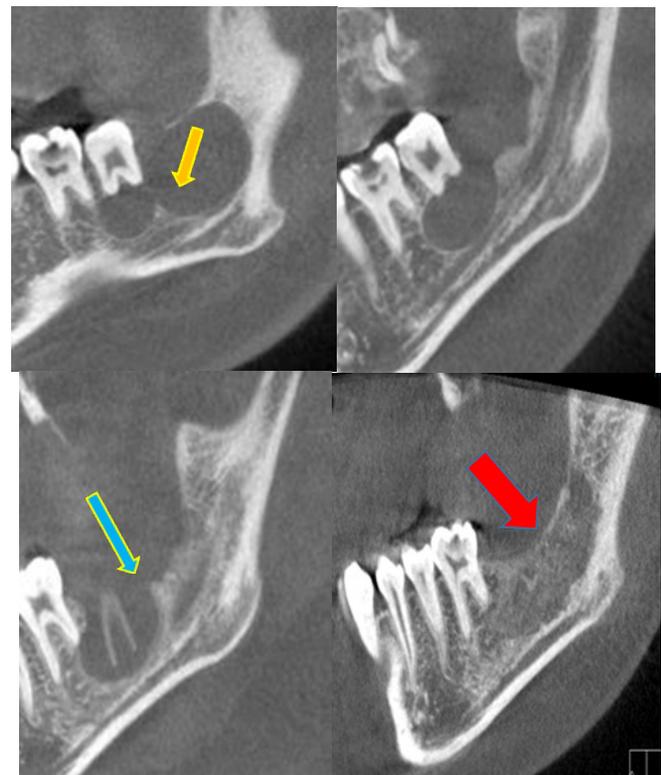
Preoperative and follow ups sagittal CBCT cuts showing lesion is reduced in volume and new bone formation till almost resolving of the lesion. A preoperative, B first follow up; new bone formation only in the distal portion of the cyst C second follow up & D third follow up; new bone formation after extraction of the involved molar. Yellow arrow pointing at the incomplete septa. Blue arrow pointing at new borders of the lesion. Red arrow pointing at new alveolar ridge formation
